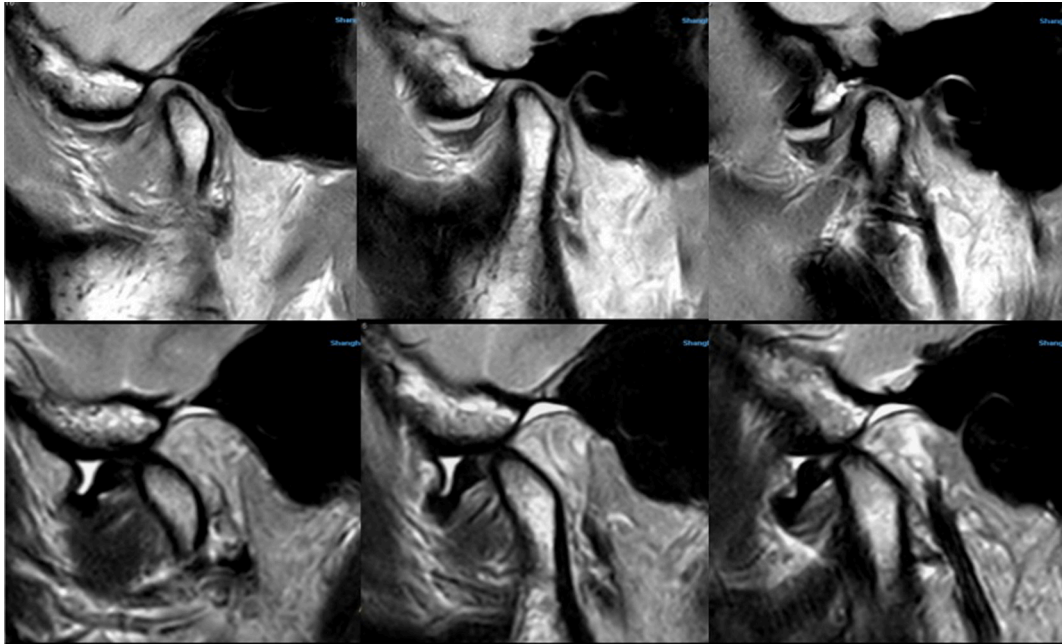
It clearly showed the relationship between articular disc and condyle by using Surface coil. TMJ MRI showed anterior disc displacement without reduction and medium amount of effusion in the upper articular cavity, which were obtained by the surface coil (Upper images were OSag PDWI with closed mouth, lower images were OSag T_2 WI with opened mouth). The surface coil has better contrast although the signal decays very fast with the increasing in the depth of object, which can make the disc–condyle complex displayed clearly. OSag, oblique sagittal; T_2 WI, T_2 weighted image; TMJ, temporomandibular joint.
